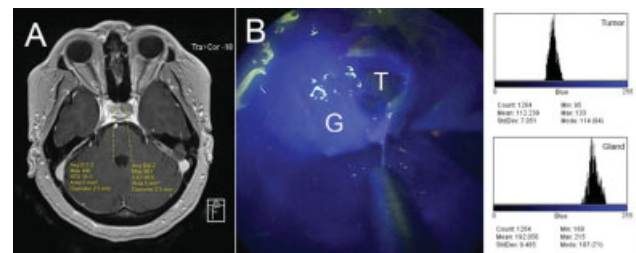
(A): Axial post contrast MRI showing the measurement of signal intensity of the pituitary gland and the adenoma. (B) Intraoperative endoscopic ICG scene showing the measurement of the blue color value of both the pituitary gland and the adenoma.
